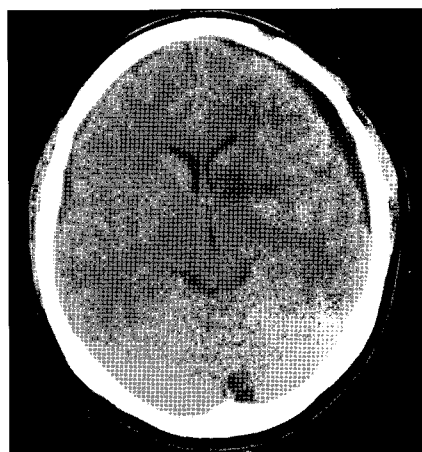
A brain computed tomography after surgical trapping of the left A1 segment showing an infarction of the left head of caudate nucleus and subdural fluid collection in left fronto-temporo-parietal convexity.
